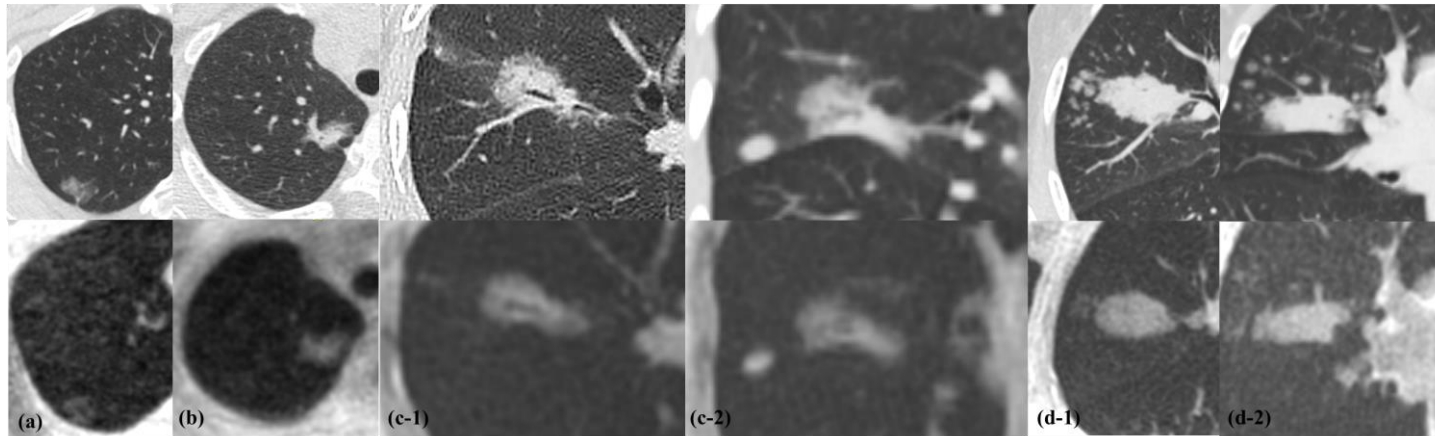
Representative cases of lung adenocarcinoma in CT and UTE-MRI (a) GGO dominant part solid nodule (PSN) with pT1a and micropapillary and/or solid (MP/S) negative at surgical pathology without recurrence within 3 years, (b) Solid dominant PSN with pT1c and MP/S positive at surgical pathology without recurrence within 3 years, (c-1) Axial and (c-2) coronal images of solid dominant PSN with pT1c with MP/S positive at surgical pathology with recurrence at 7 months after surgery, (d-1) Axial and (d-2) coronal images of solid mass with pT3 with MP/S positive at surgical pathology with recurrence at 6 months after surgery.
